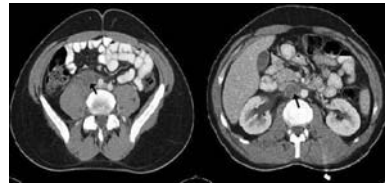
CT abdomen with contrast
